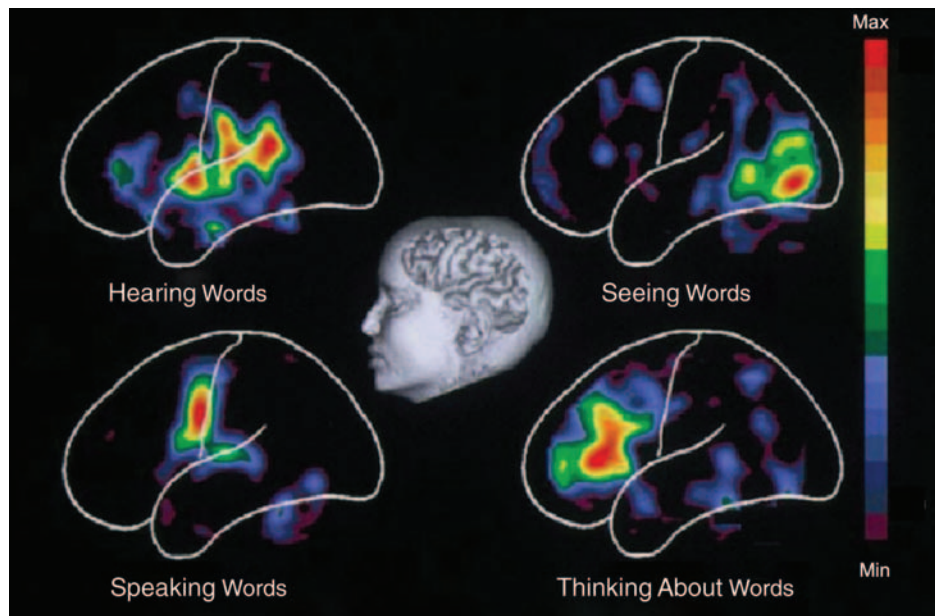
A classical PET finding: visual versus auditory brain activity. Early PET scans showing different speaking, seeing, hearing, and internally generating words (Posner and Raichle, 1994). Notice that visual, auditory, motoric, and speech production regions appear to be activated. However, the surrounding brain outline (white lines) is only approximate. In more recent brain images, the functional activity would be superimposed upon a structural MRI of the same subject’s brain. *Source:* Posner and Raichle, 1994.
